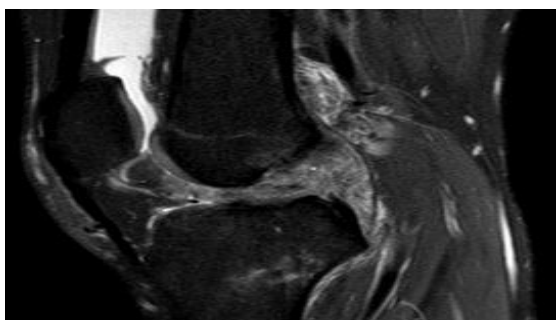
MRI Appearance of ACL Tear
